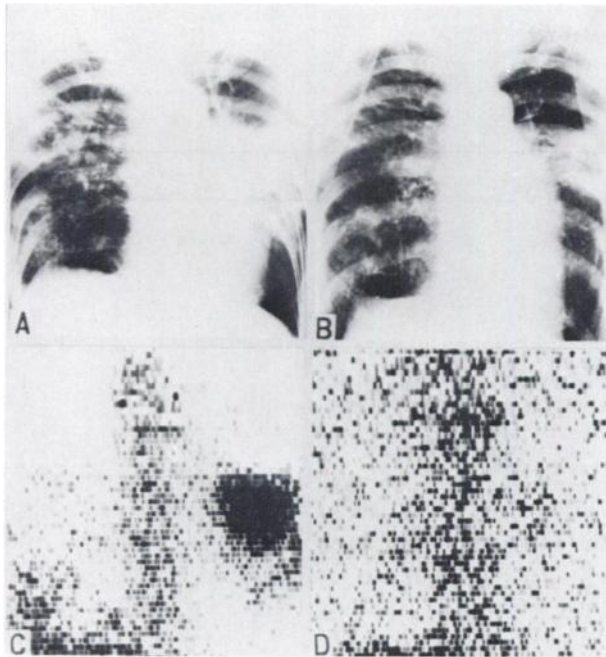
(A) Chest x-ray shows exudative lesion containing cavities in left middle, left lower, and right middle lung field. (C) Scintigram is clearly positive. (B,D) After chemotherapy with ampicillin almost all of x-ray shadows or positive scan disappeared.
